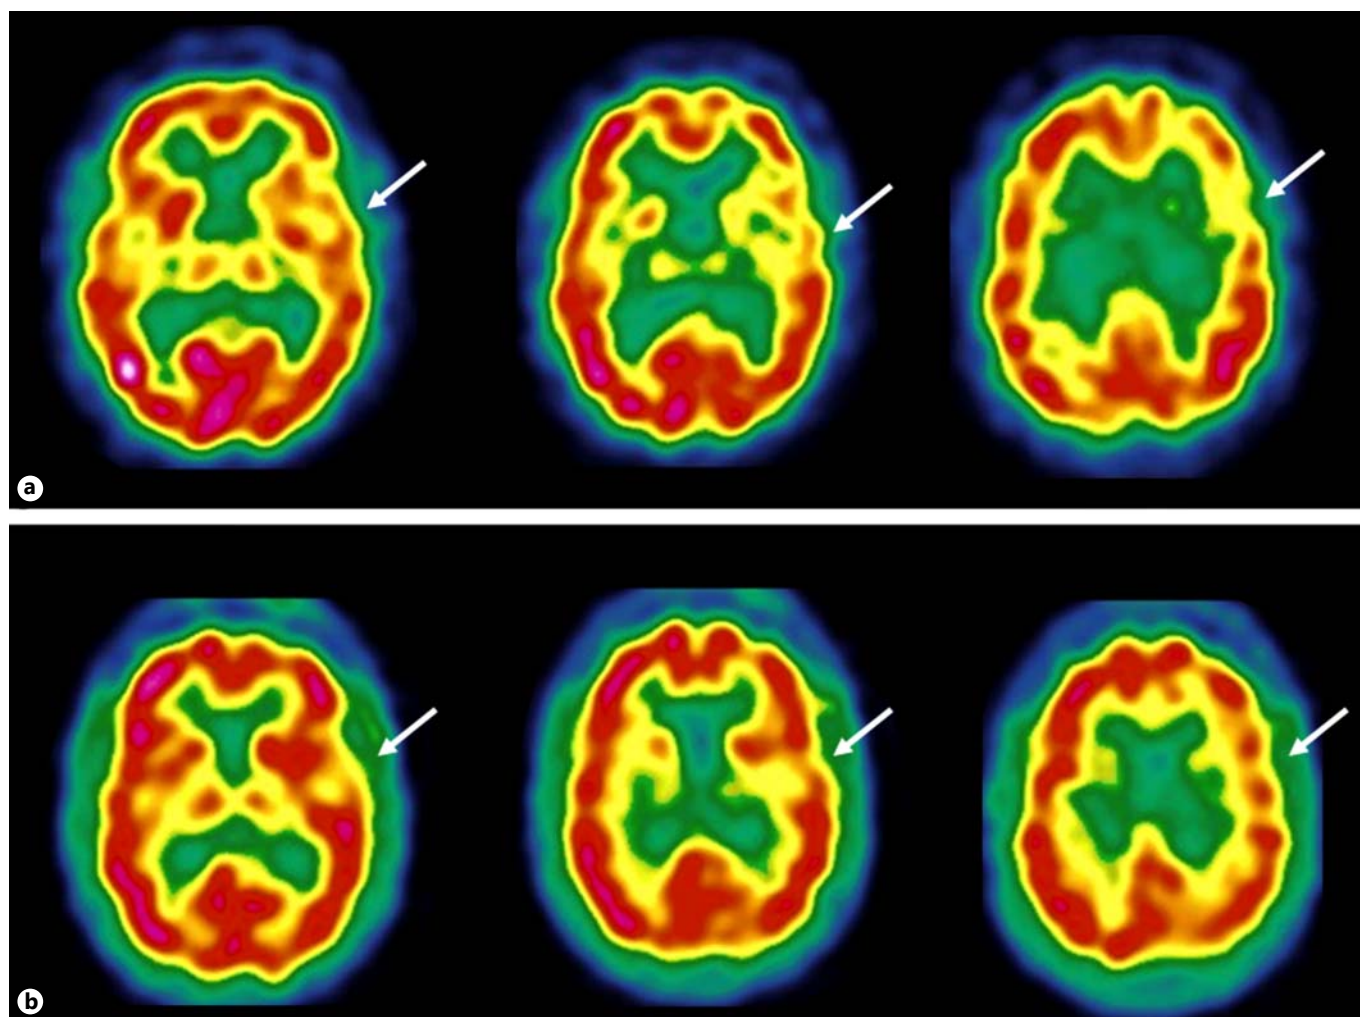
Cerebral perfusion SPECT before (a, Time 0, with ^{99m}Tc -ECD radiotracer) and 1 month after (b, Time 1, with ^{99m}Tc -HMPAO radiotracer): hf-rTMS showed an increased cerebral perfusion in the left frontotemporoparietal cortex (from grade 2 to
